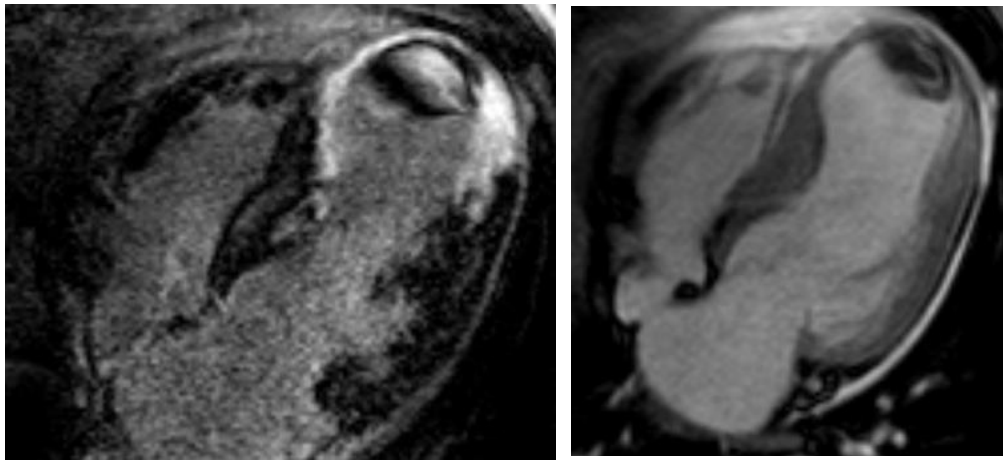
Detection of left ventricular thrombus by cardiac magnetic resonance imaging (cMRI). Left: cMRI without contrast agent; Right: cMRI with late gadolinium enhancement (MRI-LGE).
